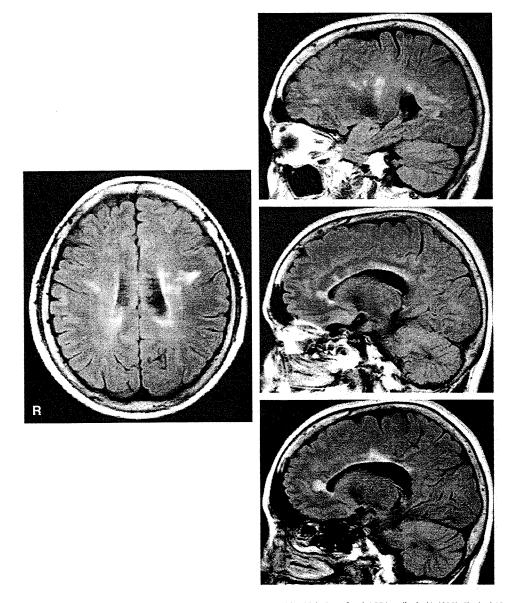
Axial and sagittal fluid-attenuated inversion recovery (FLAIR) images in an MS patient with a high titre of anti-AQP4 antibody (1:4096). She had 15 years of illness and her EDSS score was 1 at the time of the MRI scan. Note the presence of ovoid periventricular lesions typical of MS.
